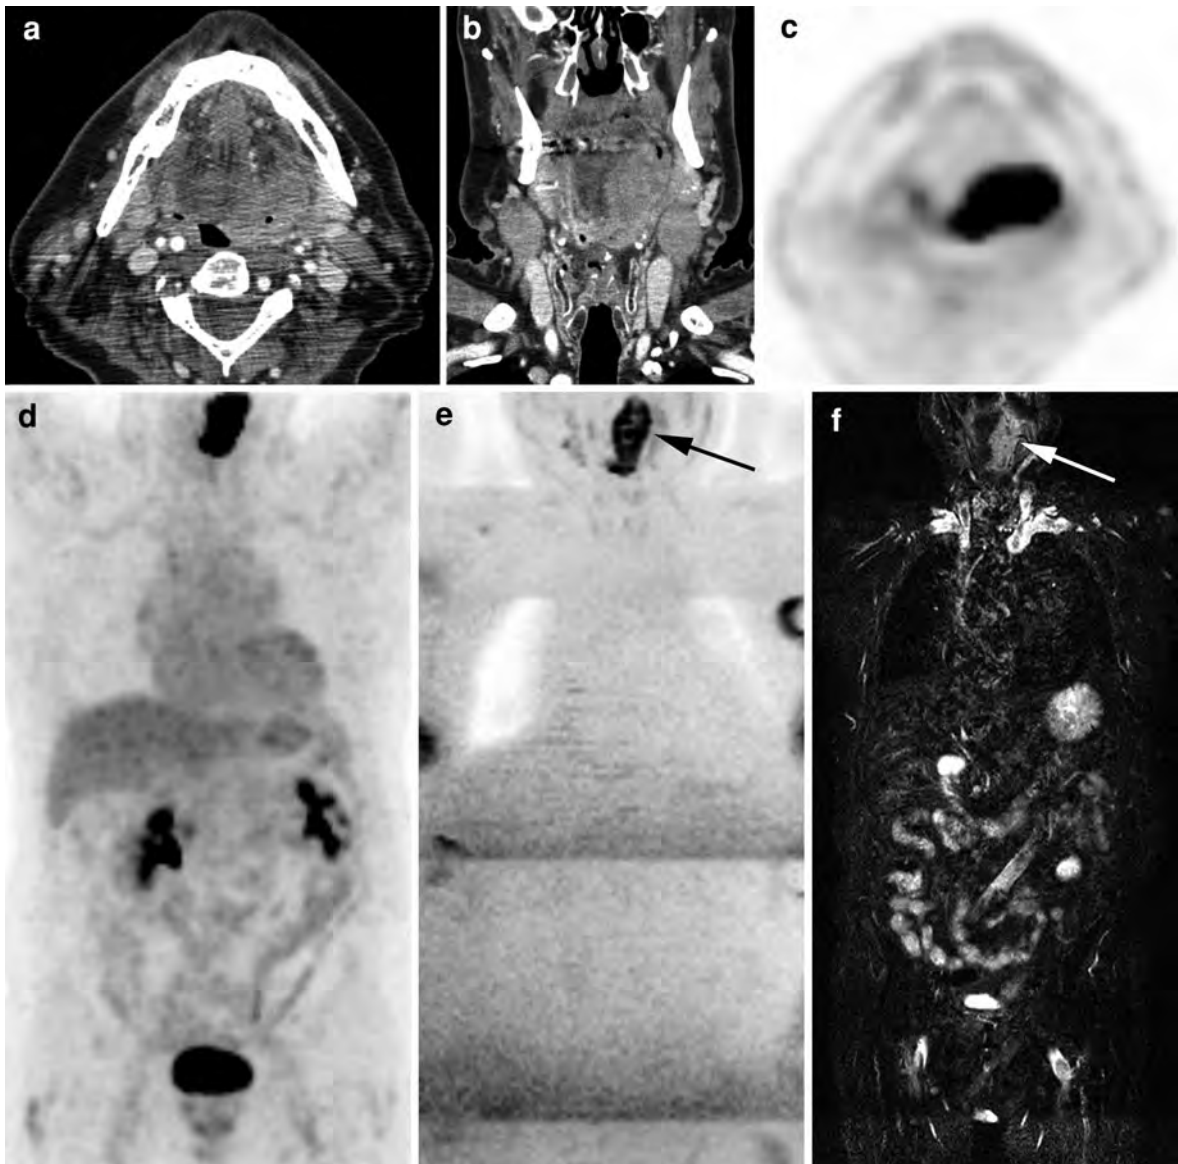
Diffuse large B-Cell lymphoma (DLBCL) of the base of tongue (BOT). a Axial and coronal contrast-enhanced CT shows large enhancing lesion centered in the left BOT. b Axial and coronal PET study: area of increased metabolism correlates well with the abnormality on CT. c, d Staging of this patient with PET shows the large primary lesion in the left BOT. No pathological metabolic activity is detected outside the neck
